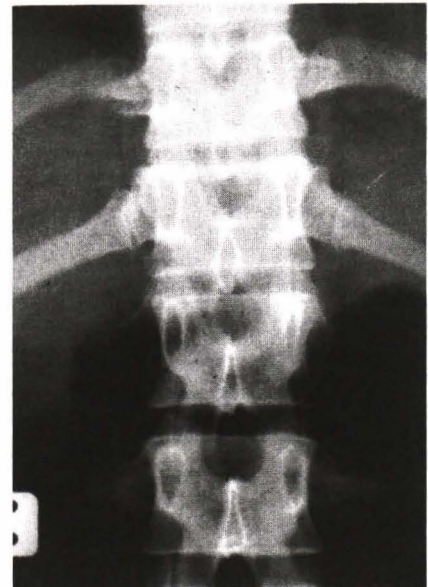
The variation of the morphology of the pedicle contour seen on the AP plain film of the normal spine.
